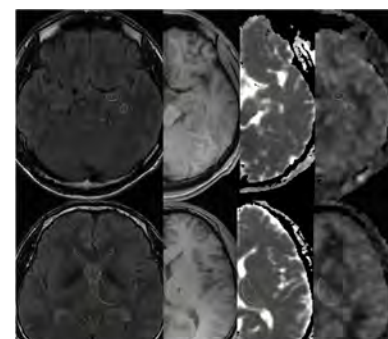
The demonstration of ROIs with images (FLAIR/T1/ADC/CBF) of a right-sided MTS patient.
